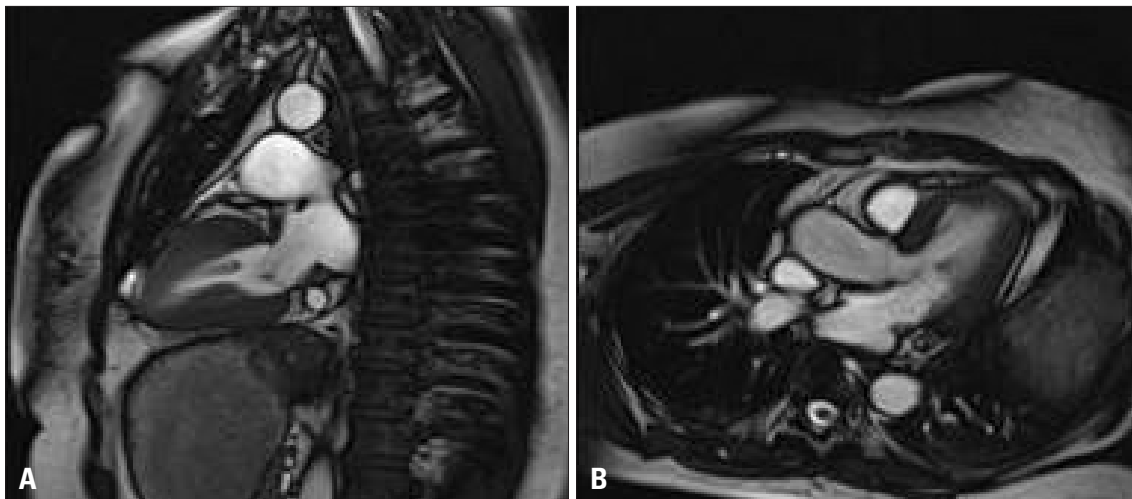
Left atrial intramural hematoma, followed by left atrial dissection, completely disappeared on follow-up cardiac magnetic resonance imaging 5 months after index surgery. A: Sagittal view. B: Transverse view.
